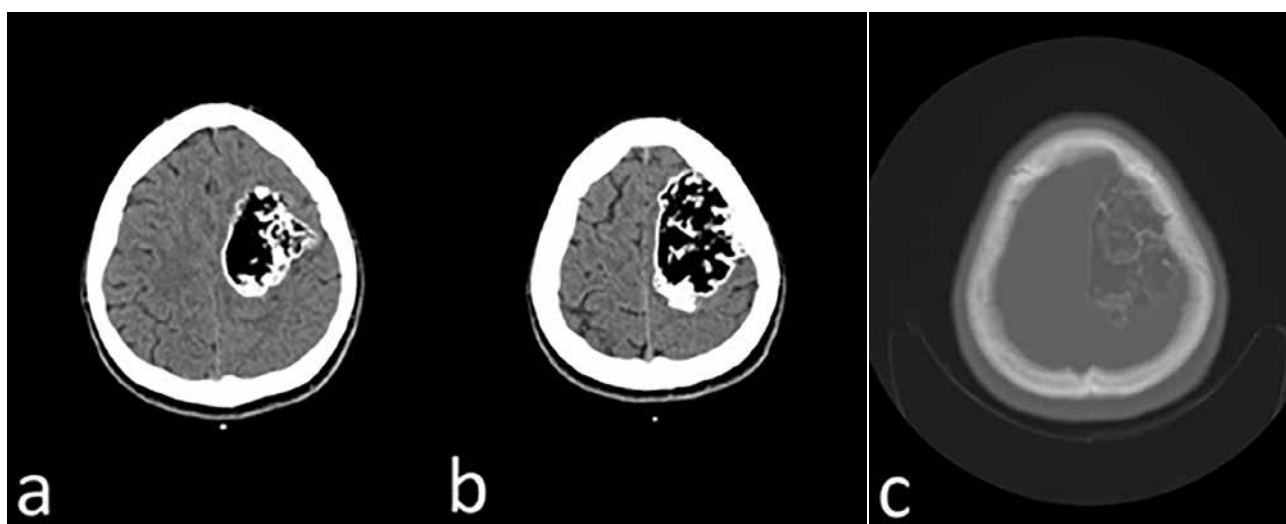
CT 2015 12 31 LSMUL KK: CT axial brain window (a, b), bone window (c): calcified lesion with fat inclusion are seen on the periphery.
